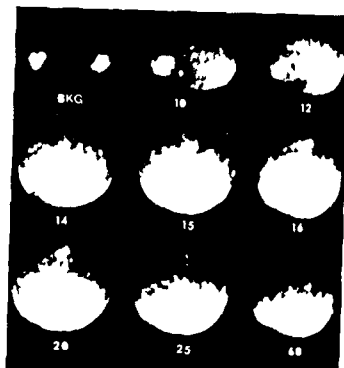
Serial lateral 1 second scintigrams of a 56 year-old male after injection of ^{133}Xe into the right internal carotid artery. There is a large local perfusion deficit (arrow) at the site of previous resection of a frontal meningioma. Elsewhere perfusion is fairly uniform although a large vascular meningioma was demonstrated angiographically in the medial posterior parietal region.
